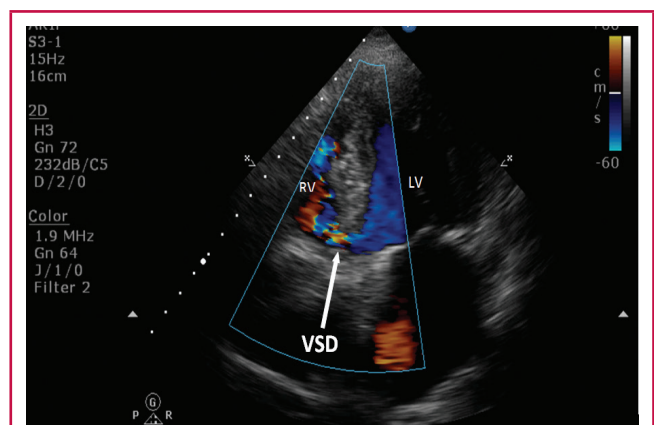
Transthoracic apical four-chamber view showing left-to-right shunt at the interventricular septum level. VSD = ventricular septal defect; RV = right ventricle, LV = left ventricle.
